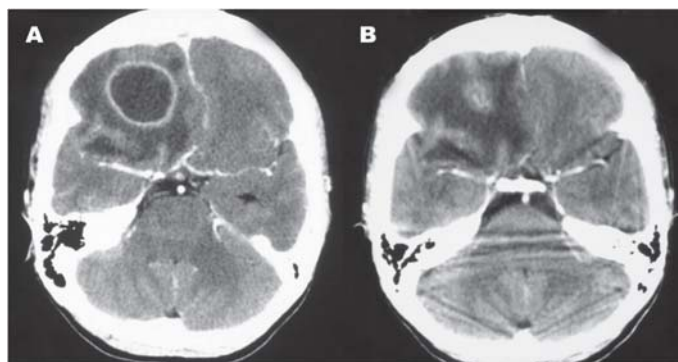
CT-scan showing a brain abscess before (A) and after (B) aspiration.
